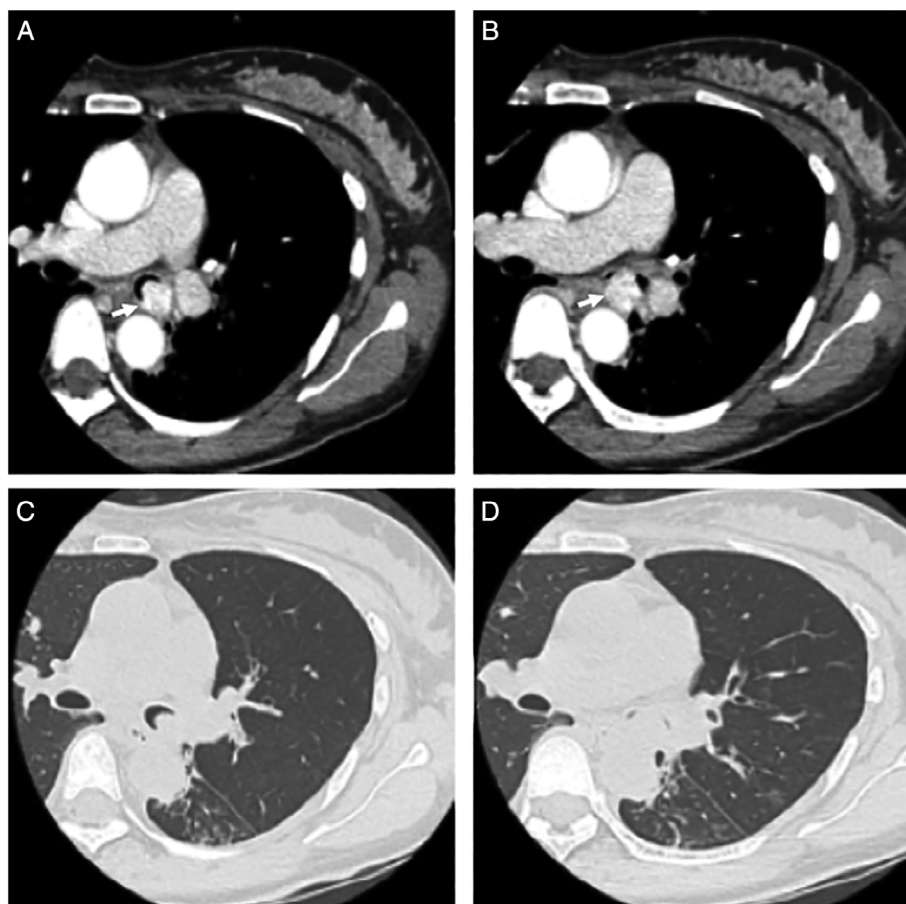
Chest computed tomography (CT) before intervention. (A, B) Contrast-enhanced CT study revealing the tumour at the main distant left carina (white arrows). The tumour is regularly round shape and densely enhanced in early phase. No lymph node metastases were detected. (C, D) Plain CT study. Left main bronchus was almost obstructed.
